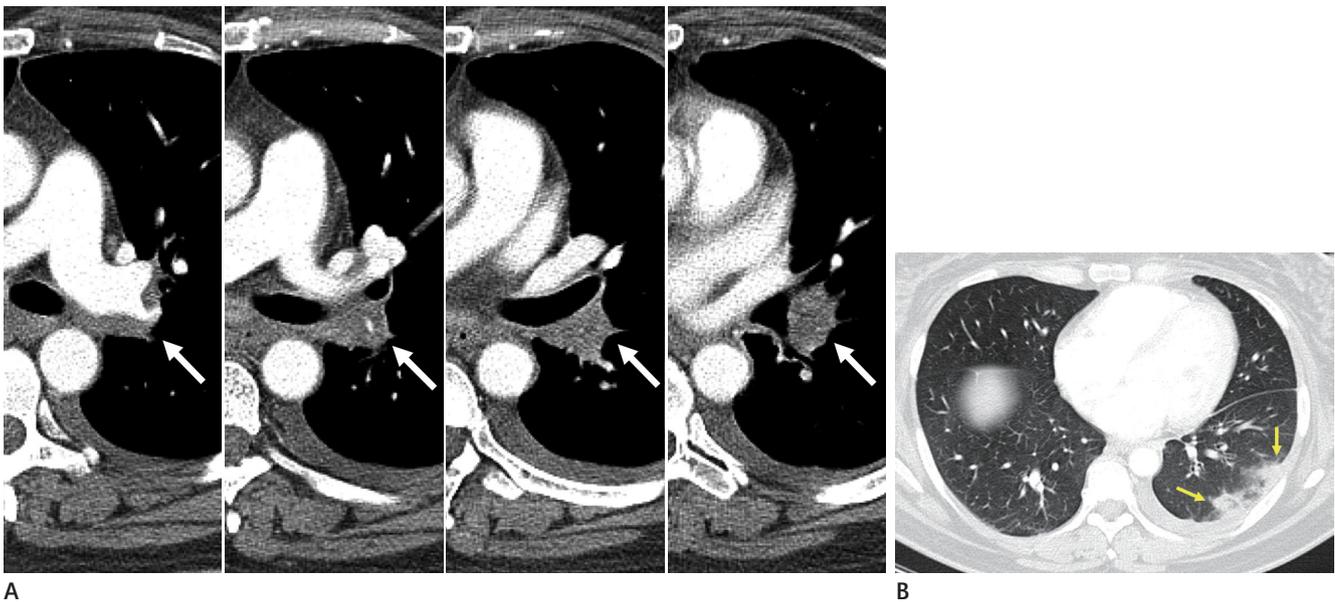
Representative CT images of localized fibrosing mediastinitis.
